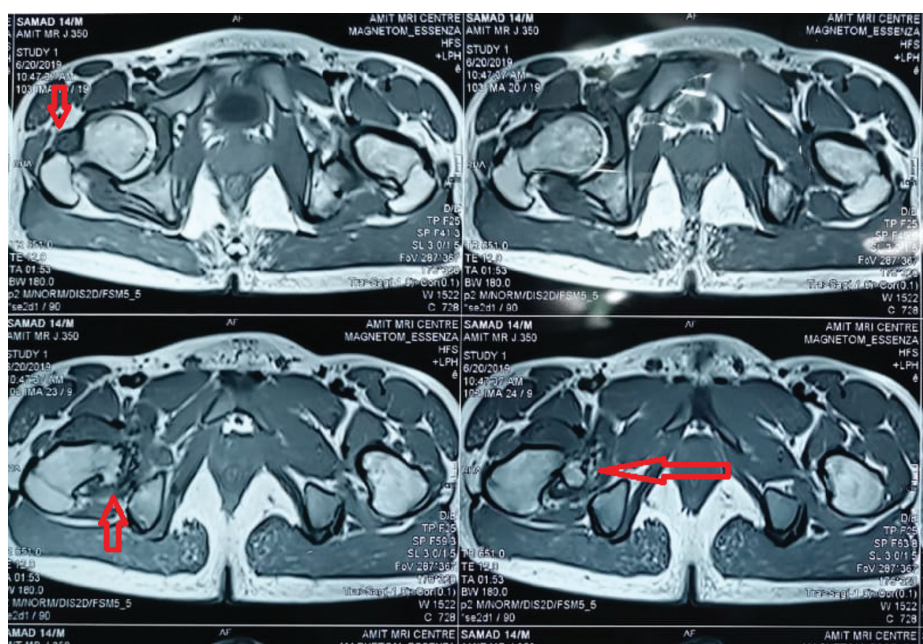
Transverse sections of magnetic resonance imaging showing multiple loose bodies in the right hip.
